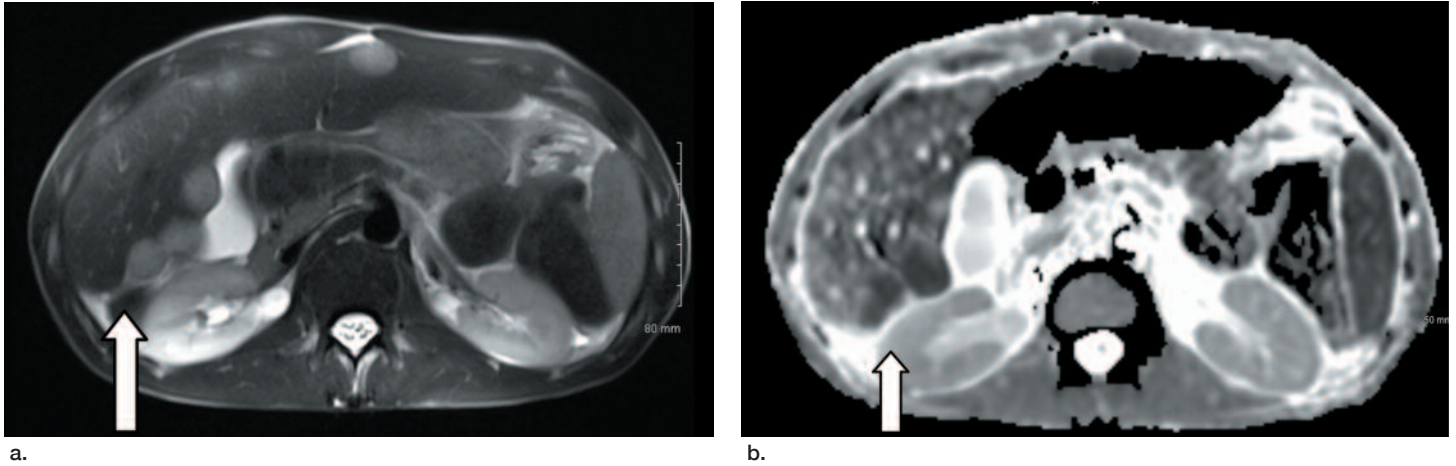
a) MRI T2 weighted imaging of the abdomen showing peritoneal metastases along glissons capsule of the liver b) An apparent diffusion coefficient map derived from diffusion-weighted imaging showing restricted diffusion in the tumor deposits.
